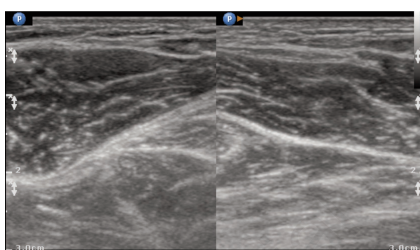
Ultrasonographic examination of the right leg showed no alterations to soft tissue.
